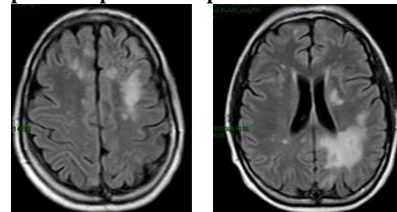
MRI showing PML with worsening in the left posterior parietal deep white matter
